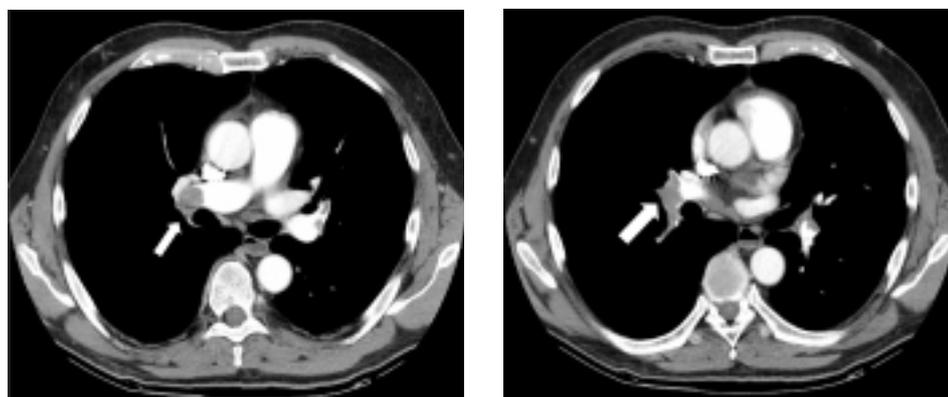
Multislice computed tomography showing pulmonary embolism involving the left pulmonary artery (arrow).
